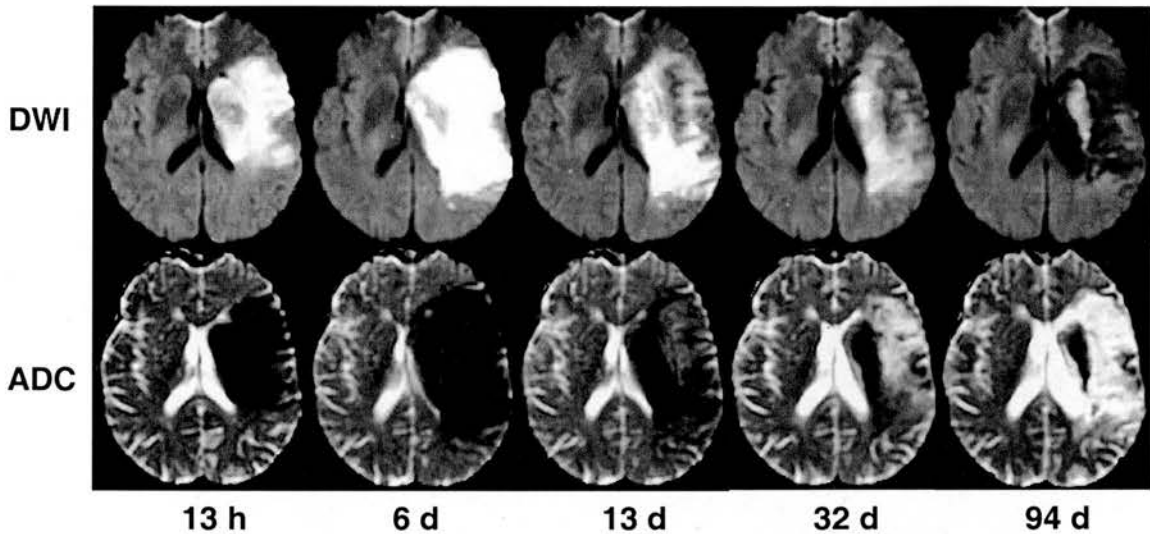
DWI and ADC images from a patient with a left hemisphere ischaemic lesion from 13 hours (h) to 95 days (d) after stroke onset. Note the compression of the left lateral ventricle between 13 hours and 13 days and subsequent *ex vacuo* effect at 94 days after stroke onset.
